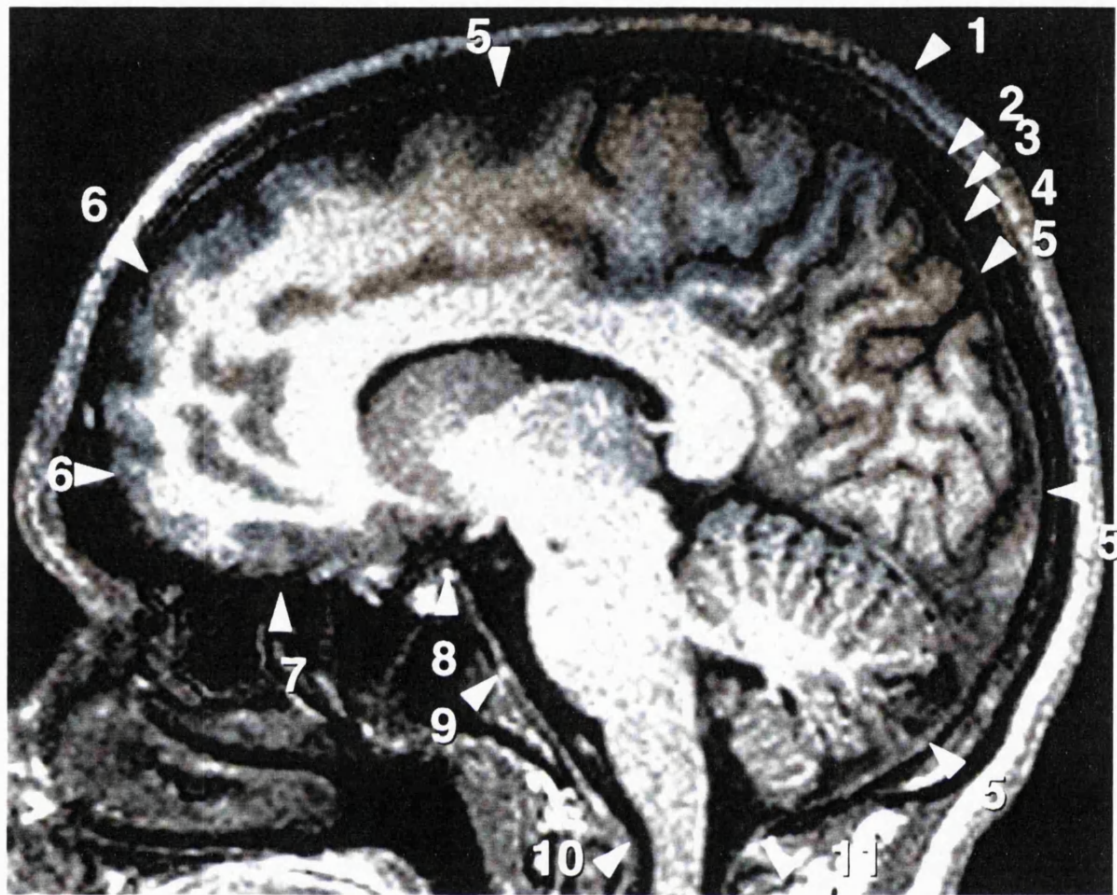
MR image showing landmarks for measurement of ICV. The scalp (1) is visible as a bright line, with the outer table of the skull immediately below it (2). The diploë (3) lies between the outer table and inner table (4). The dura mater (5) lies below the inner table and is generally visible as a white line. Where it is not, the cerebral contour (6) is outlined. Other landmarks are the undersurfaces of the frontal lobe (7), the dorsum sellae (8), clivus (9), and at the craniovertebral junction the attachment of the dura to the anterior (10) and posterior (11) arch of C1 (from Van Paesschen, 1997).
